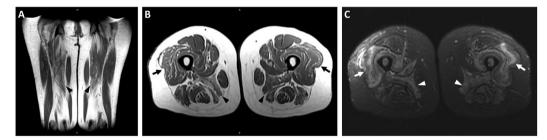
Magnetic resonance imaging of the thighs. The thighs demonstrate symmetrically diffuse muscular hyperintensity on T1WI, indicative of fatty replacement with bilateral involvement of the quadriceps (arrow) and adductor muscles (arrowhead) (A, coronal view; B, axial view) and edematous change on T2-weighted IDEAL image (C, axial view). T1WI, T1-weighted imaging; IDEAL, iterative decomposition of water and fat with echo asymmetry and least-squares estimation.
